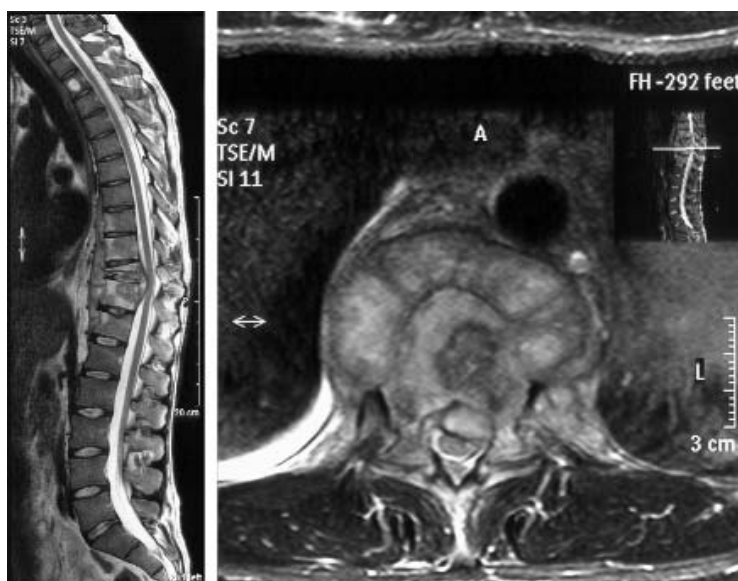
MRI: sagittal and axial cross-sections: T1 and contrast medium in a patient with specific spondylitis (atypical mycobacteria: *Mycobacterium xenopi*) at the level of thoracic vertebral body 10
